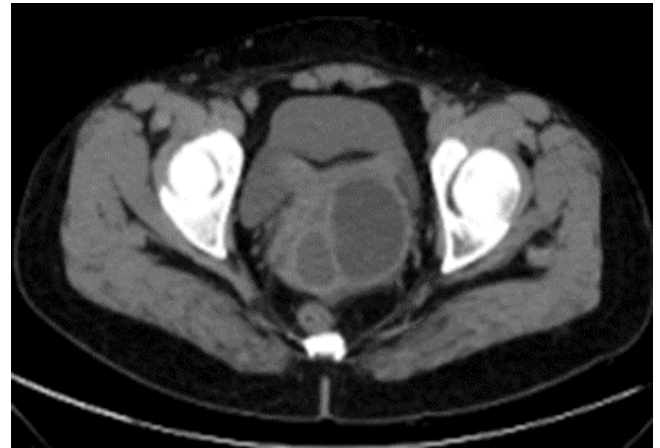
Total abdominal CT
